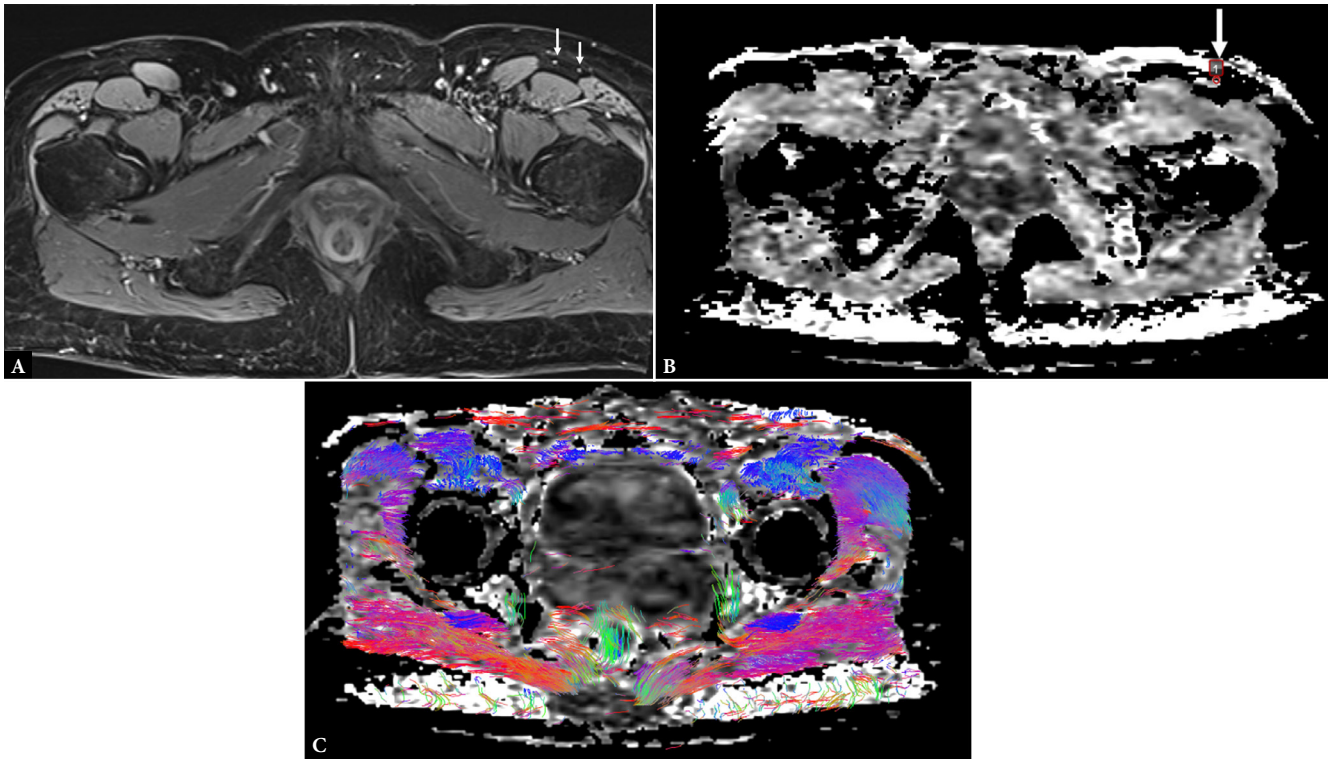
Axial STIR image (A) at the proximal thigh demonstrating the bifurcation of the anterolateral femoral cutaneous nerve on the symptomatic side (arrows). The nerve appears mildly enlarged with increased fluid-sensitive signal, consistent with early neuropathic involvement along its intra-thigh course. Fractional anisotropy map (B) combined with diffusion-tensor tractography (C). The region of interest (arrow), positioned approximately 4 cm caudal to the inguinal ligament and coregistered with the corresponding axial T2-weighted image, shows a marked FA reduction on the affected side (0.33 vs 0.61) accompanied by a less compact and more dispersed fiber trajectory. These findings indicate localized microstructural disruption of the nerve
